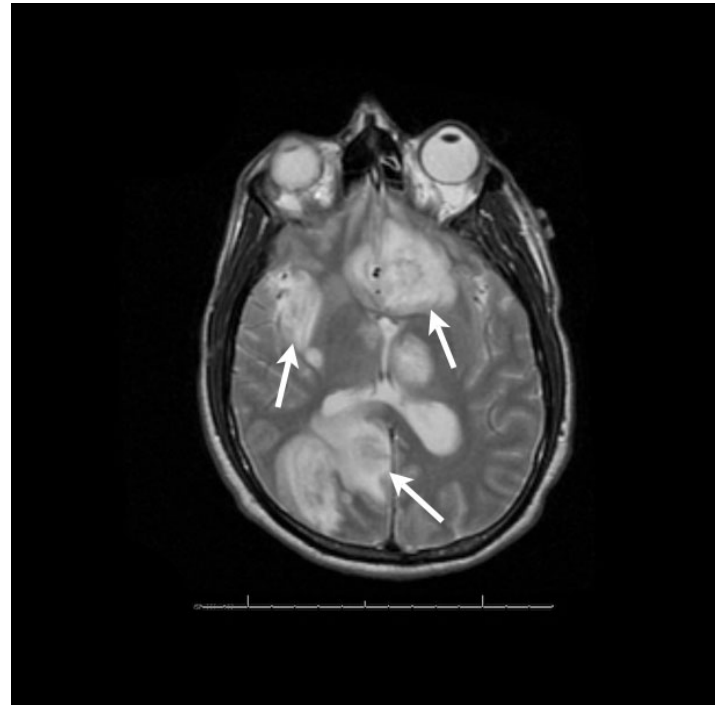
Magnetic resonance imaging with gadolinium with multiple enhancing lesions (arrows).
